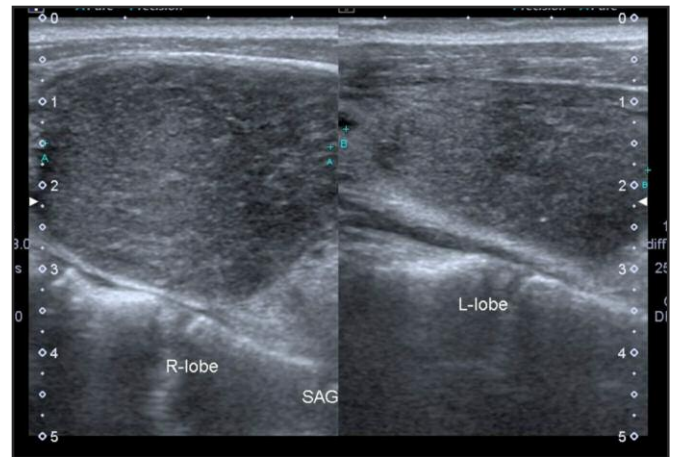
Ultrasound of the thyroid gland showing an enlarged right lobe of thyroid with coarse echotexture.
